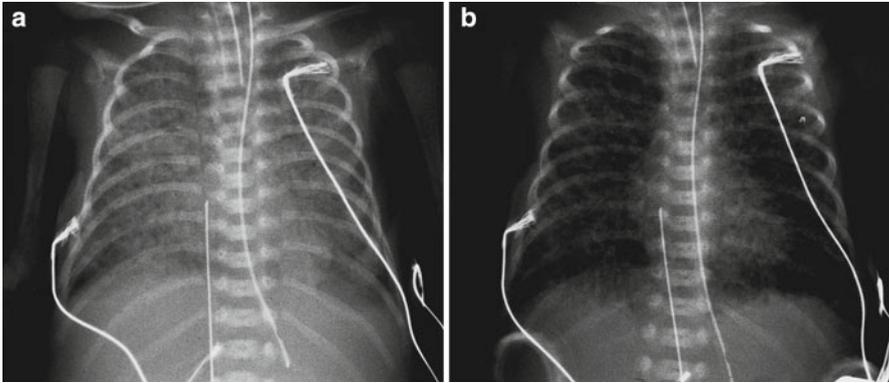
Evolution of pulmonary hemorrhage in an infant with RDS. Chest radiographs show typical features of severe PIE on the fifth day (a) and severe pulmonary hemorrhage on the seventh day (b). Heart size is normal
